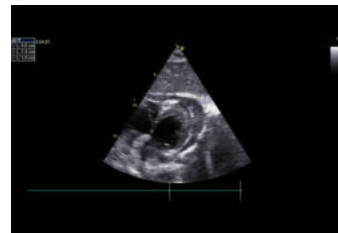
transthoracic echocardiogram subcostal view visualizing a porridge-like pericardial effusion
